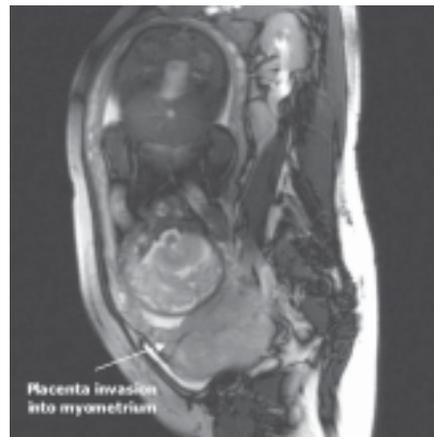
Magnetic resonance imaging of placenta accreta.
